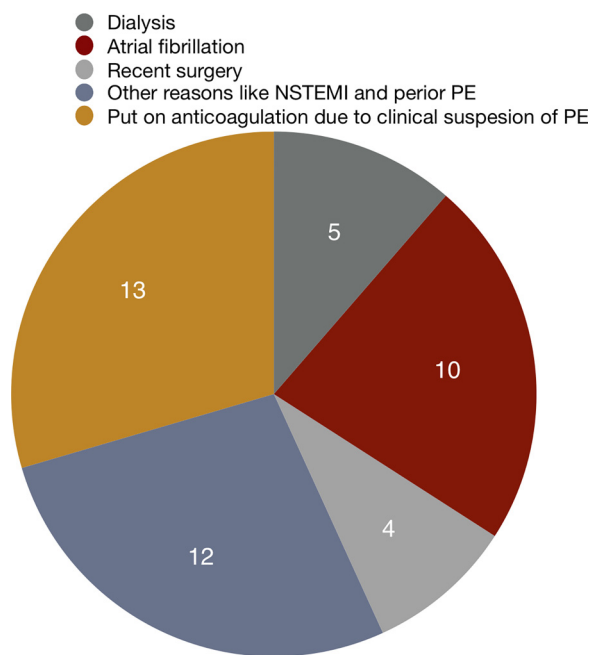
Number of patients on anticoagulation at the time of MRI examination.
